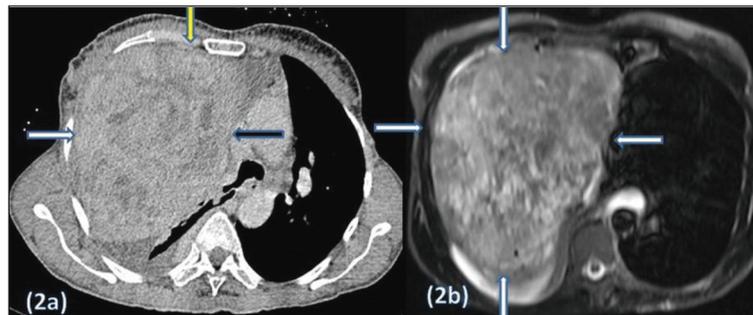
A solid mass measuring approximately 165×125×190 mm, filling the right hemithorax almost completely and pushing the heart and mediastinal structures to the left, was observed. a) Computed tomographic view of the thorax, b) Magnetic resonance view of the thorax.
